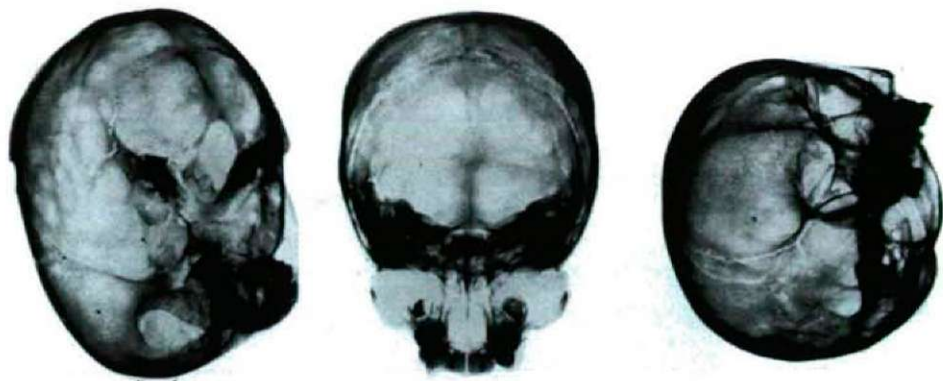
Kiszombor, cemetery of the Migration Period grave 299 (1300). Cranial X-ray pictures: "hair on end".
